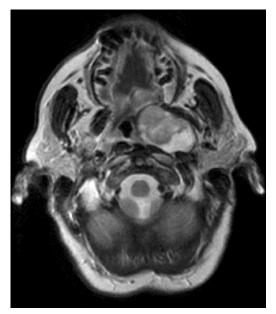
T2-weighted axial MRI of a prestyloid parapharyngeal space pleomorphic adenoma that underwent TORS with good results.
